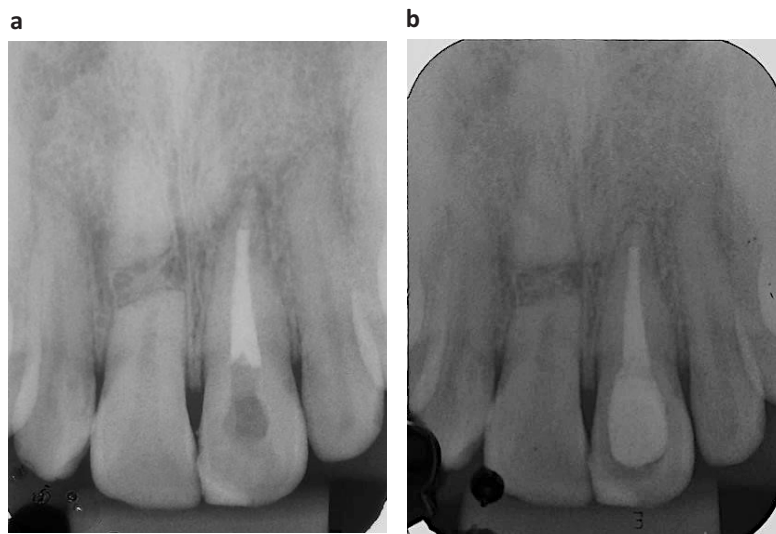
a) Final periapical radiograph showing root canal obturation of the treated tooth with proper adaptation of the filling material and absence of voids. b) Follow-up radiograph demonstrating maintenance of periapical integrity and absence of resorptive signs, indicating successful endodontic treatment during the follow-up period.
